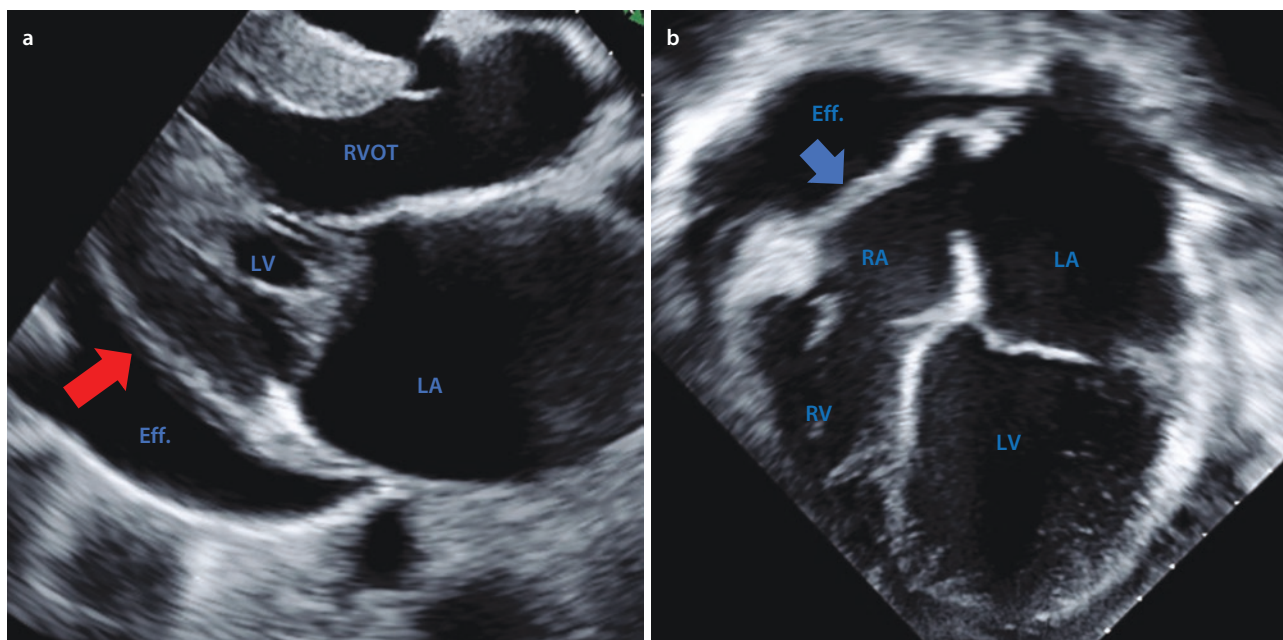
a Moderate to large sized pericardial effusion (Eff.) present on FoCUS parasternal long-axis view. The effusion is increased along the left ventricular free wall (red arrow). b Right atrial collapse is noted (blue arrow)
